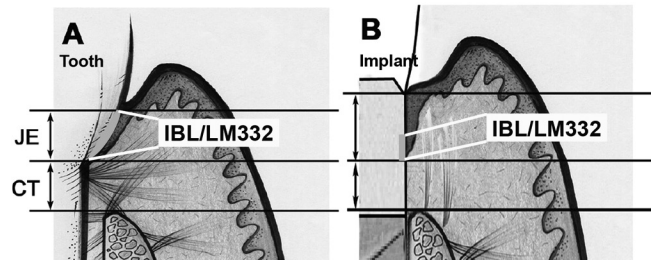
Comparison of epithelial adhesion to the natural tooth (A) and dental implant surface (B). Epithelium attaches to the implant by a longer junctional peri-implant epithelium (JE) as compared with the tooth. Internal basal lamina (IBL) containing laminin 332 (LM332) may be present only in the apical third of the implant-JE interface. CT, connective tissue.
